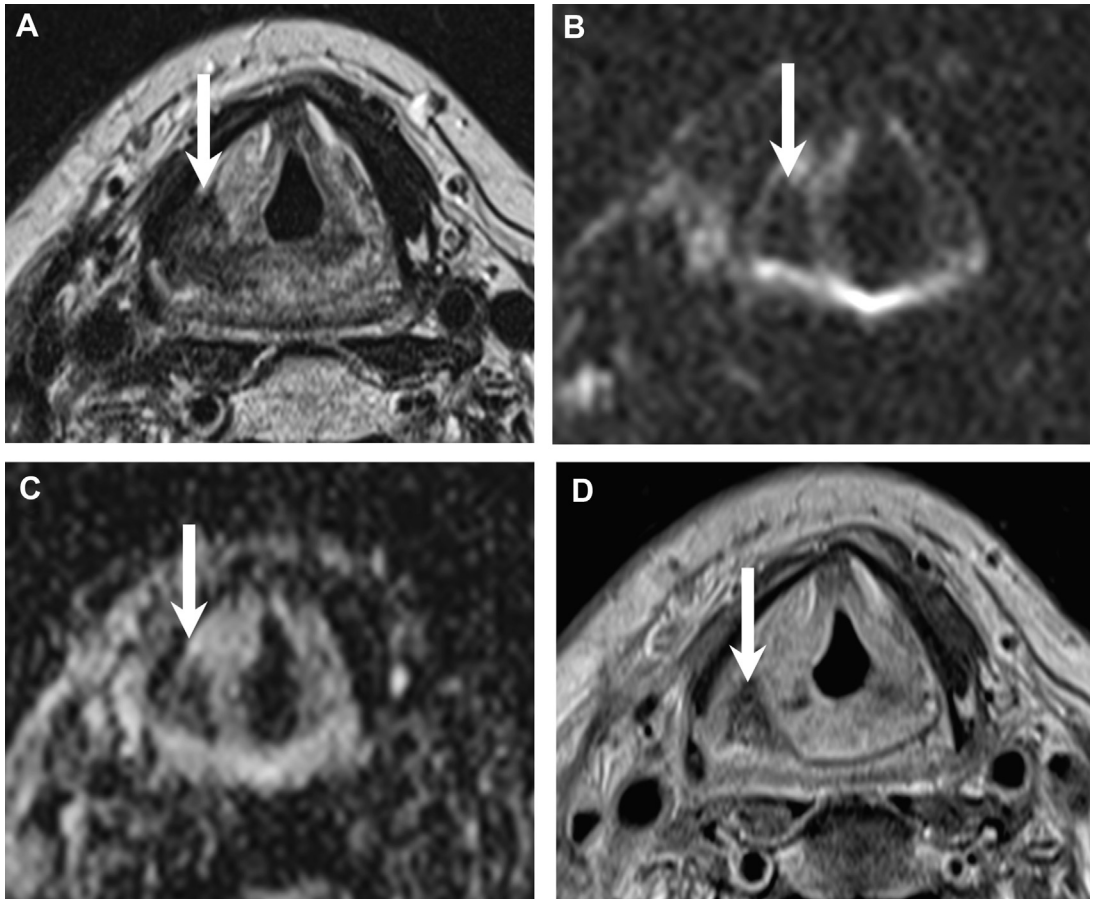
Characteristic MR imaging features of late fibrosis/post-treatment scar tissue. MR imaging obtained 3 months after radiotherapy for an SCC of the piriform sinus. Axial T2 (A), b1000 (B), ADC (C), and contrast-enhanced T1 (D) show a well-defined strongly hypointense area on T2 (similar signal as muscle tissue) with minor contrast enhancement (arrows in A and D). Note low signal on b1000 and ADC map (arrows in B and C) because the tissue is very rich in collagen fibers (T2 blackout effect).
